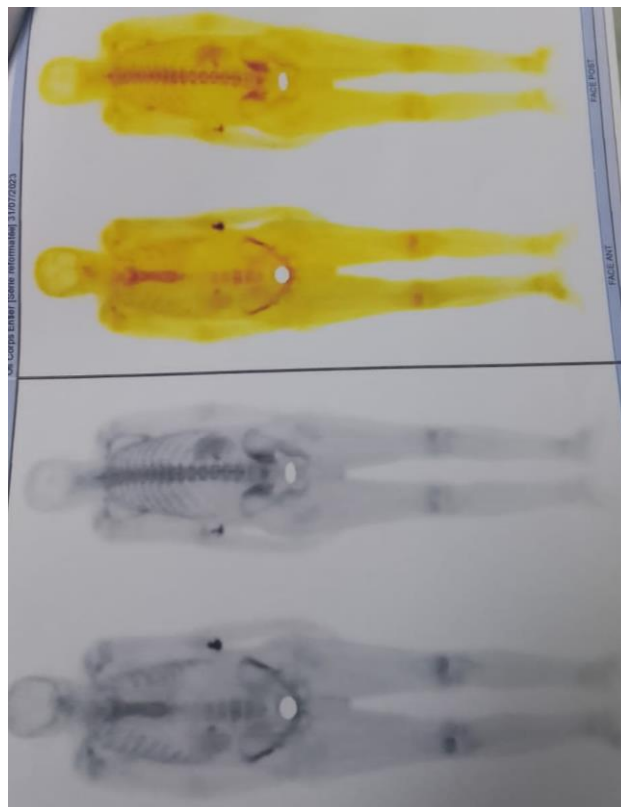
Bone scintigraphy (SPECT-CT MDP Tc 99m) with intracardiac radiotracer uptake
